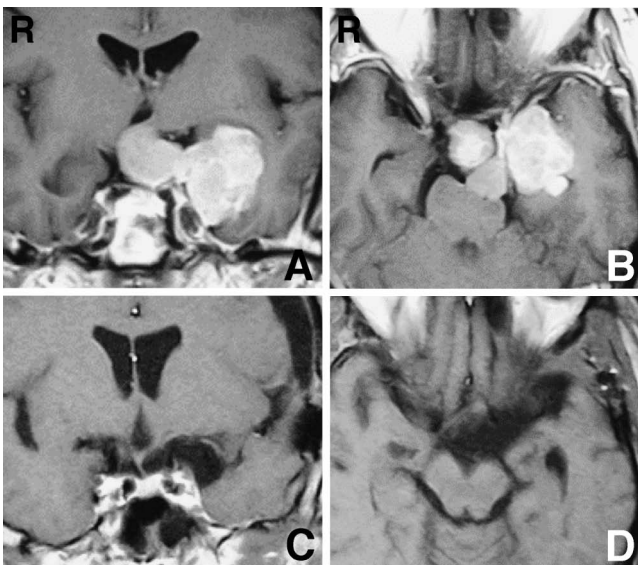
Case 9. Preoperative T₁-weighted magnetic resonance (MR) images with contrast medium (A, B) showing a suprasellar meningioma extending to the left, and postoperative T₁-weighted MR images with contrast medium (C, D) showing removal of the tumor.
